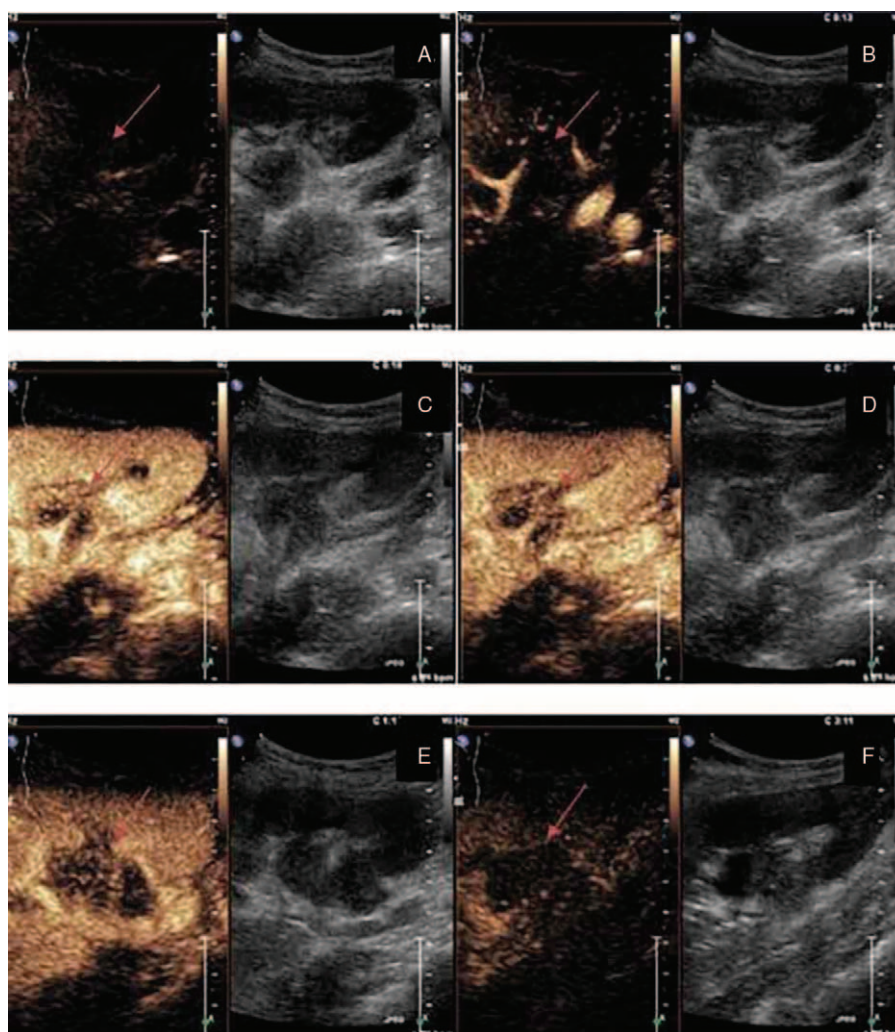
A series of contrast-enhanced ultrasonography (CEUS) images. (A) The initial image from the start of CEUS (0 s after injection) showed hypoechoic renal cortex, medulla, and mass, and bright background echoes in the perinephric and renal sinus fat. (B) Imaging from the cortical enhanced phase (13–20 s after injection) depicted hypoechoic mass at 13 s. (C) Two obviously heterogeneous enhancing masses were evident in the image at 18 s. (D) Nephrographic phase (30 s after injection) CEUS imaging depicted initial decrease in enhancement in the mass, earlier than in the cortex. (E) Imaging depicted hypoenhancement in the mass against the enhanced background of the renal cortex. (F) End of CEUS examination image at 3 min shows washout of enhancement of the renal cortex, medulla, and mass. Throughout the CEUS examination, all images of the masses showed progressive peripheral enhancement with central nonenhancement. CEUS = contrast-enhanced ultrasonography.
